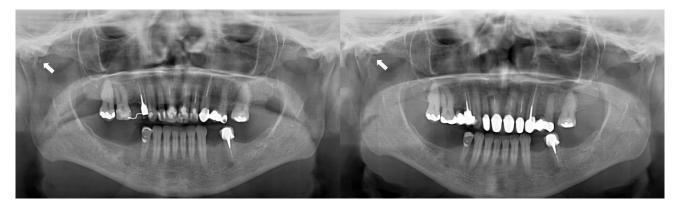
Panoramic radiograph shows loose solitary intra-articular body in the right temporomandibular joint space (arrow) at initial consultation (left) and 2-year follow up (right).
